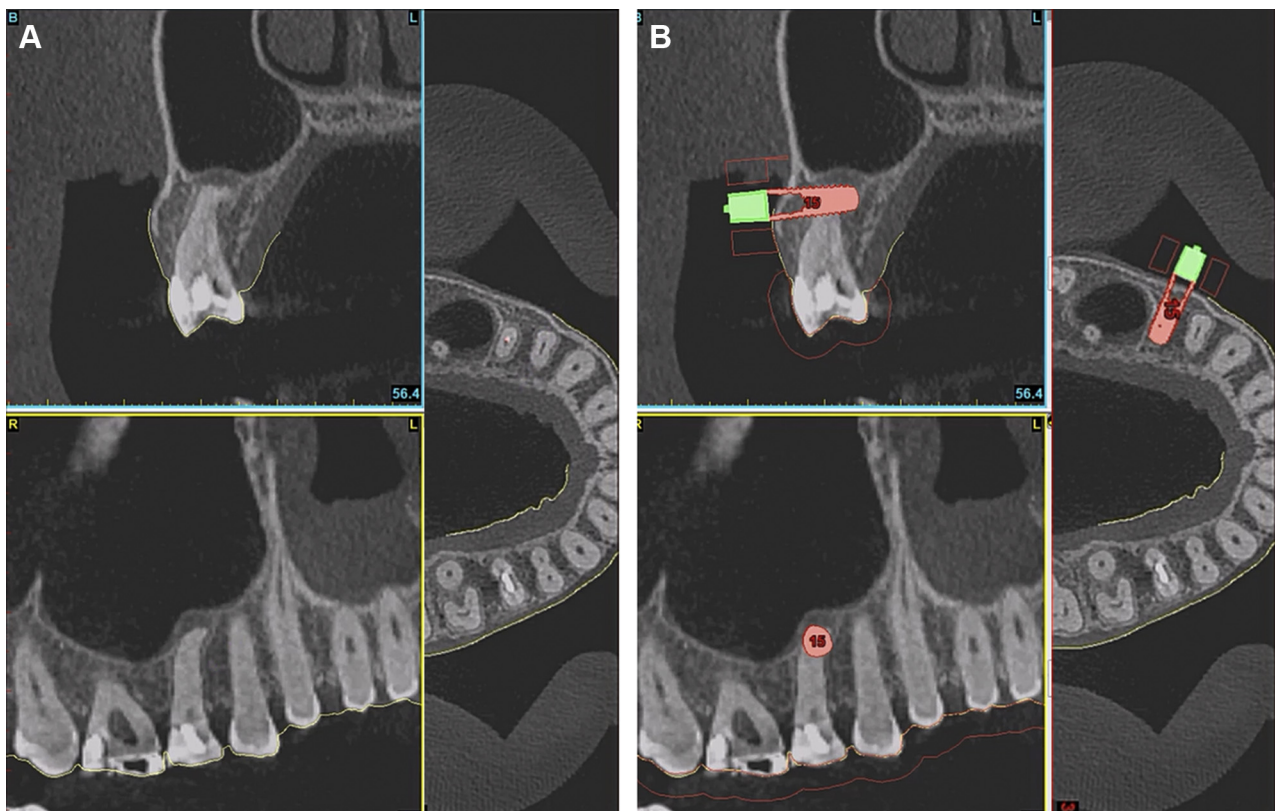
A, Cone-beam computed tomography image of right maxillary second premolar with unsatisfactory root canal treatment and apical periodontitis. The proximity to the maxillary sinus is evident. B, Virtual planning of guided surgery avoiding any damage to sinus bone wall.
